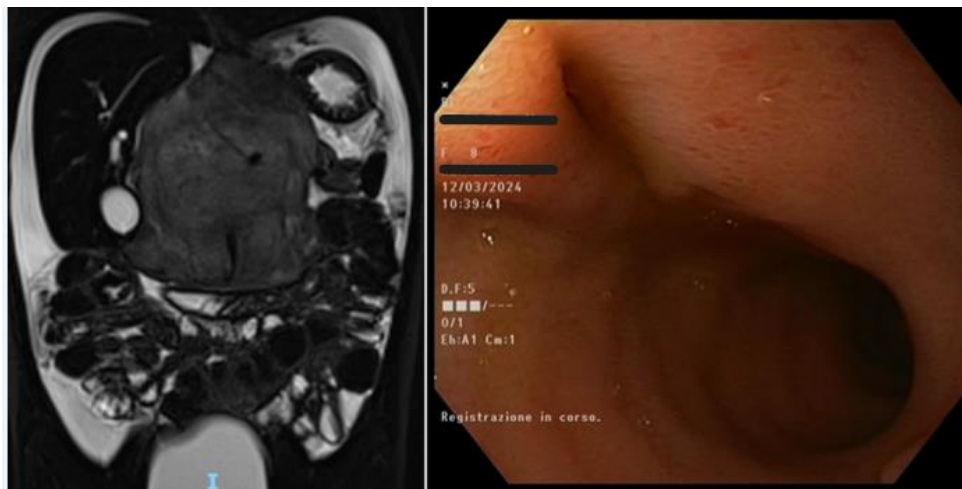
Postoperative MRI showed complete resolution of the intrahepatic bile ducts dilatation. Endoscopy revealing the spontaneous dislodgment of the LAMS device, alongside a stabilized cholecystoduodenostomy.
